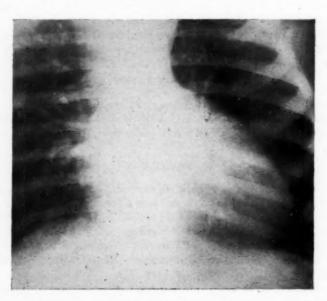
Case 1. A 6-foot posteroanterior chest radiograph. The shadow of the great vessels is narrow, and there is moderate cardiac enlargement. The left middle third of the cardiac contour is convex and the left lung appears to be oligemic. The main pulmonary artery cannot be defined with certainty.
